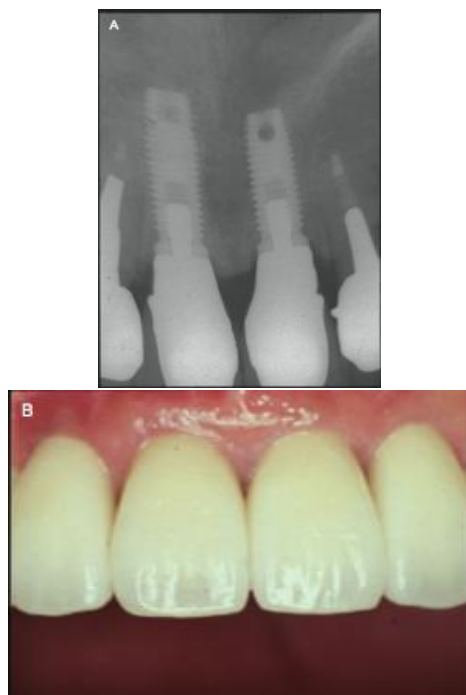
Intraoral radiographs at cementation of the final restorations. Note the remaining height of the newly formed interproximal bone tissue; B Final restorations seated in place
